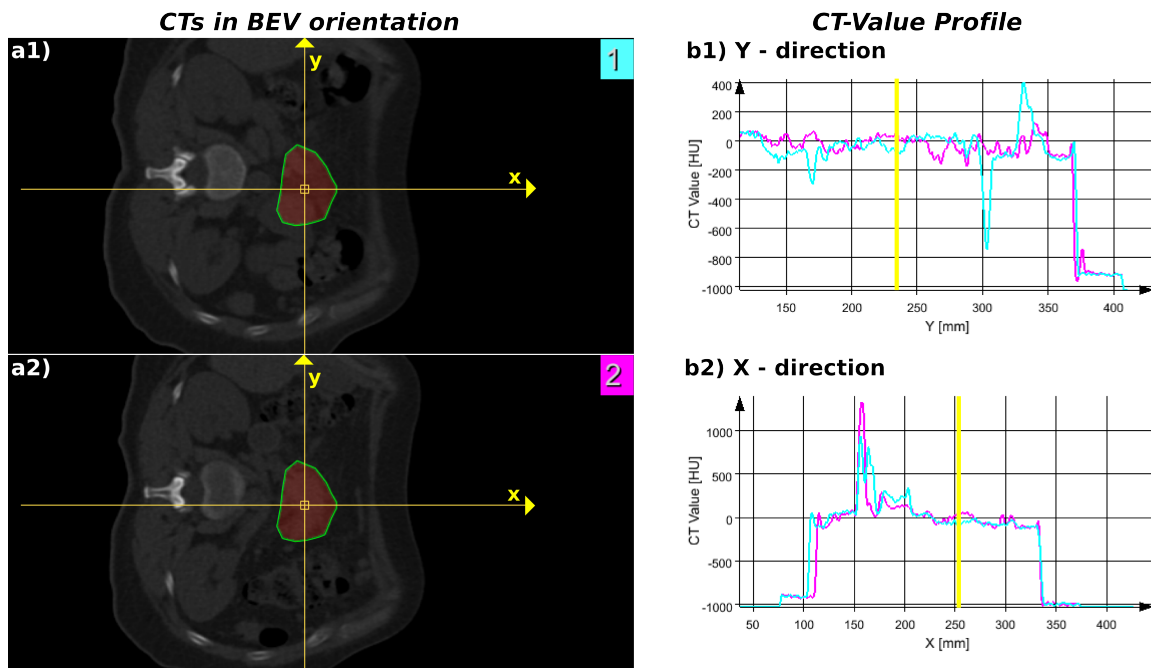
Comparison of the CT_{plan} (a1) and CT_4 (a2) for the patient A4, using the unidimensional CT value variation along the axis x (i.e., the posterior beam incidence) and y.
